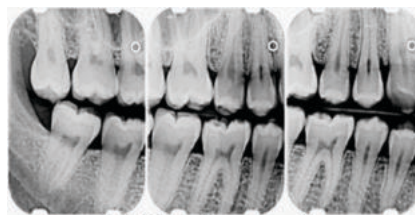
Vertical bitewing radiograph (Carranza 2012)
